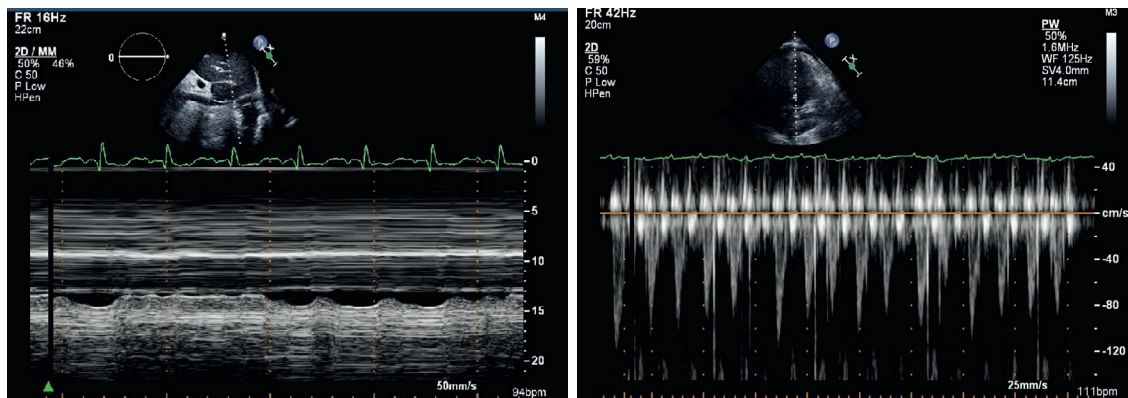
■ IVC and LVOT velocities in hypovolemia. An IVC <1.5 cm with >50% respiratory collapse suggests intravascular hypovolemia. PWD of the LVOT shows respiratory variation in velocities. IVC, inferior vena cava; LVOT, left ventricular outflow tract; PWD, pulse wave Doppler.
